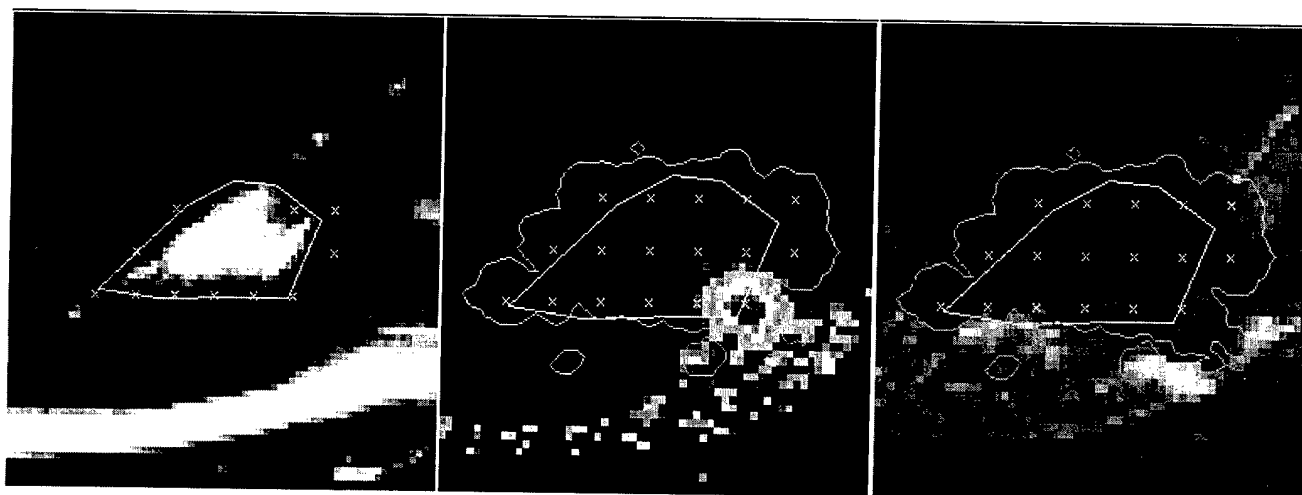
Volume sonication by using focused ultrasound. (A) T2-weighted image with the target volume outline. (B) The temperature distribution measured during one of the sonications. (C) T1-weighted contrast enhanced image showing the lack of perfusion in the sonicated tumor. The Threshold thermal dose outline calculated based on the MRI derived temperature maps is also shown in the graph.
